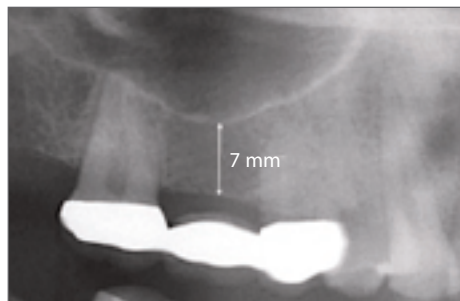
(left) Pretreatment radiograph, showing limited bone height.
